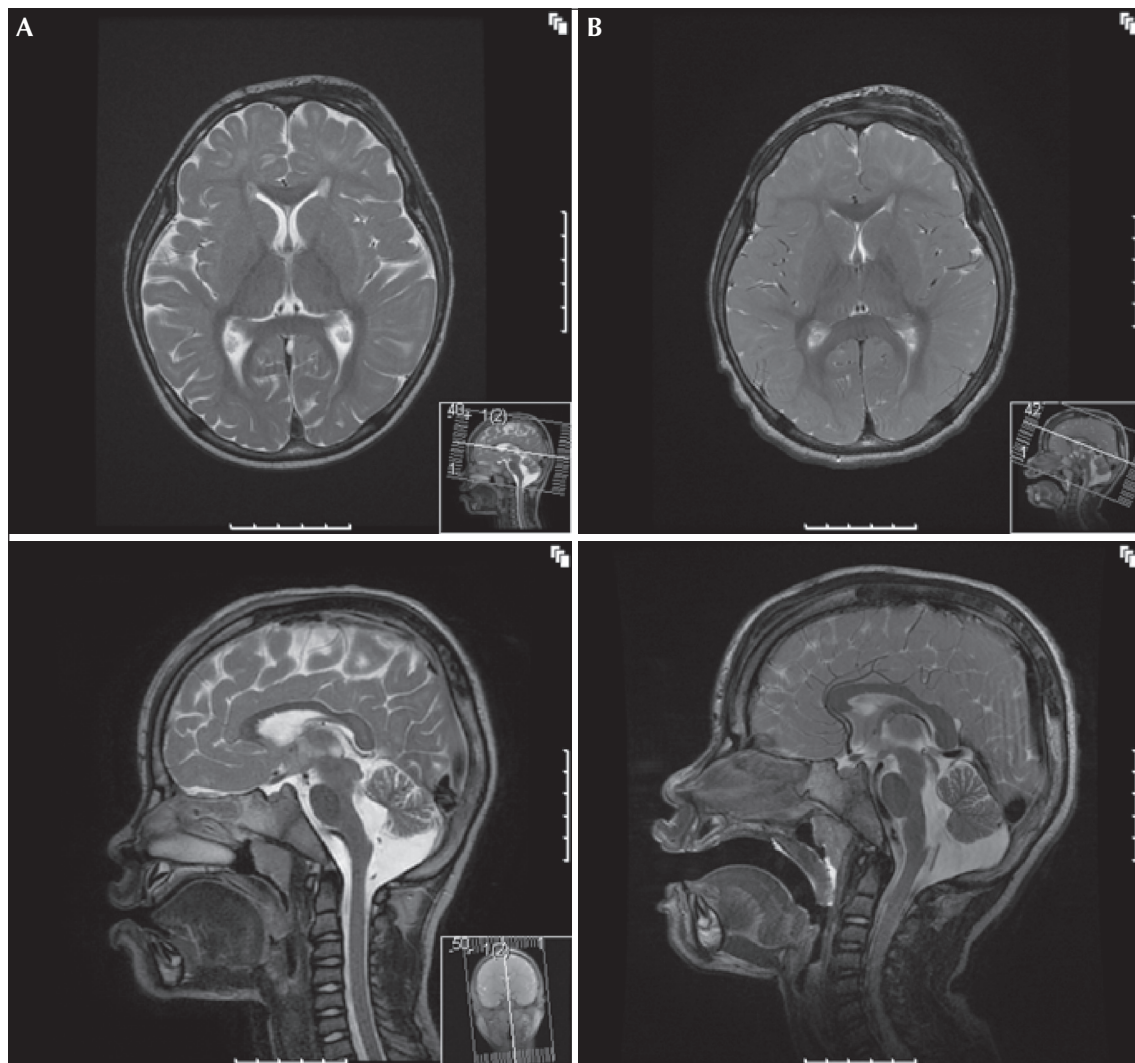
T2-weighted imaging before (A) and 4.5 months after treatment (B) showing substantial gain of brain volume (upper panels: axial plane; lower panels: sagittal plane).
